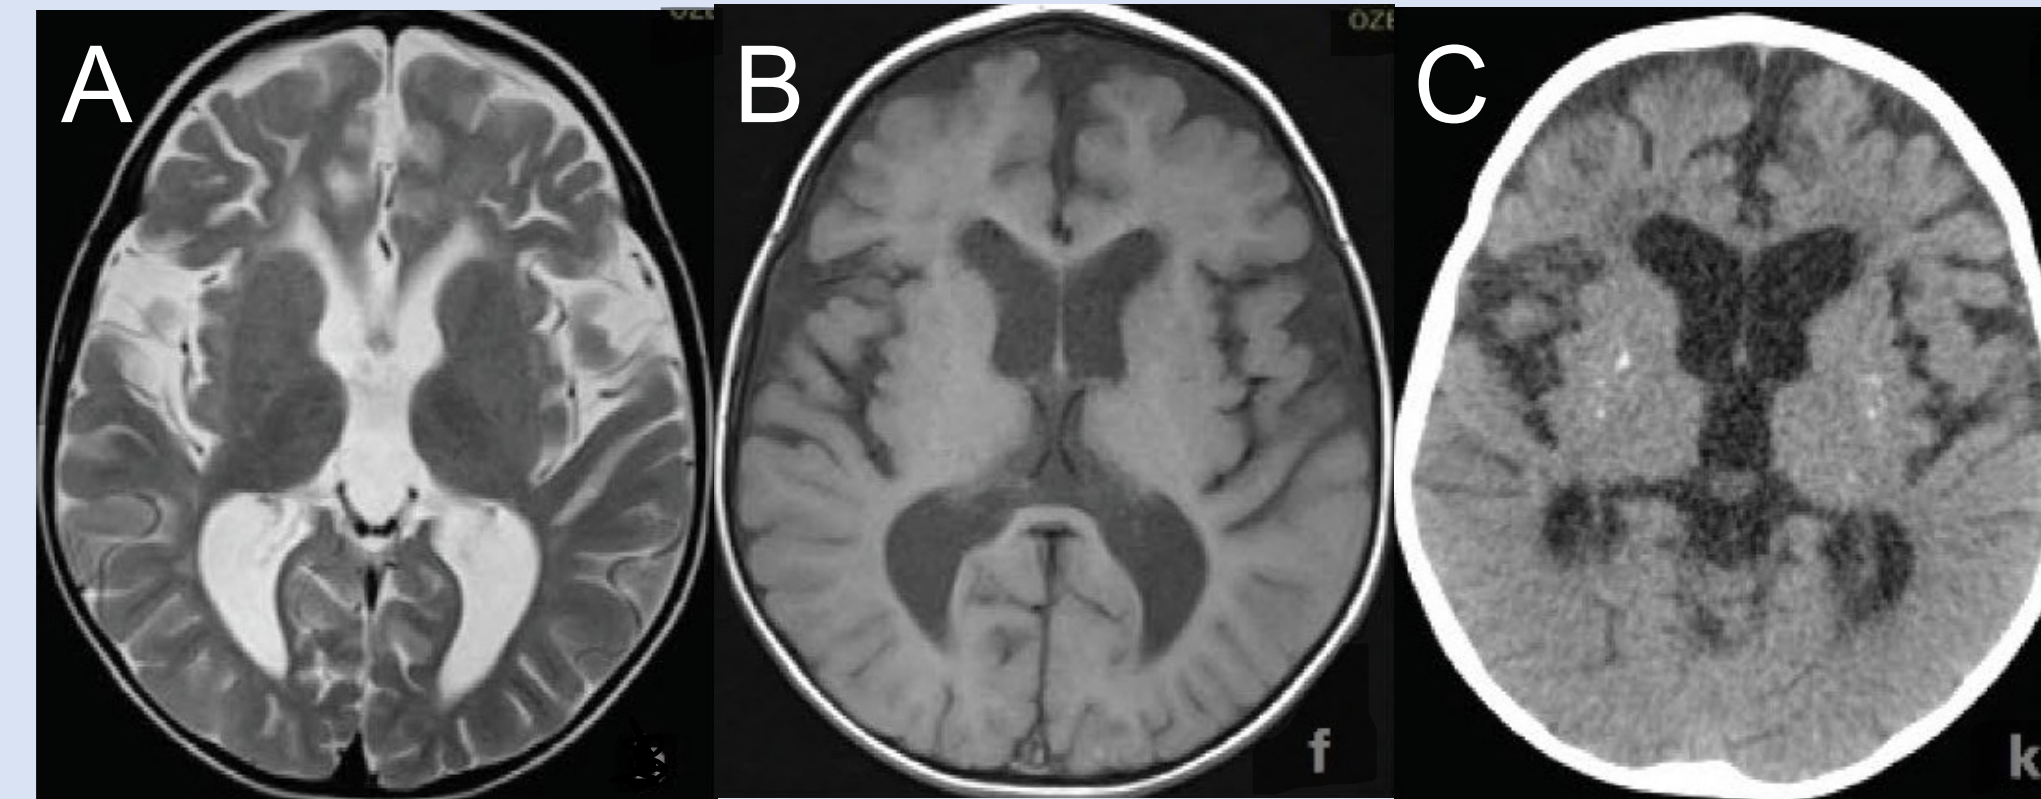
T2 and T1 axial images (A, B) of the patient with RNASEH2A mutation show ventriculomegaly, mild cerebral atrophy, no signs of calcification, Brain CT shows bilateral calcifications in the thalamus and putamen (C).
